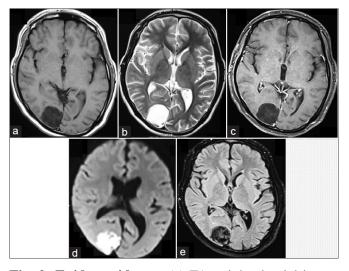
Epidermoid cyst. (a) T1-weighted axial image showing well-defined hypointense cystic lesion of the occipital lobe. (b) T2-weighted axial image demonstrates the lesion to be brightly hyperintense. (c) Post-gadolinium axial image showing no enhancement of the lesion. (d) Diffusion-weighted axial image showing the lesion to be brightly hyperintense. (e) Fluid attenuated inversion recovery axial image showing internal heterogeneity giving dirty mop-like appearance.
